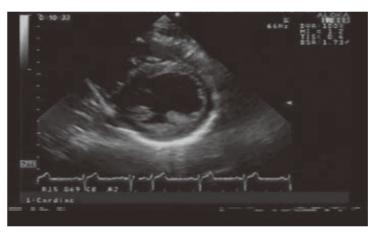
The lower (leaflet edge) of the left ventricle from the parasternal short axis view in B mode. Two papillary muscles were shown.
